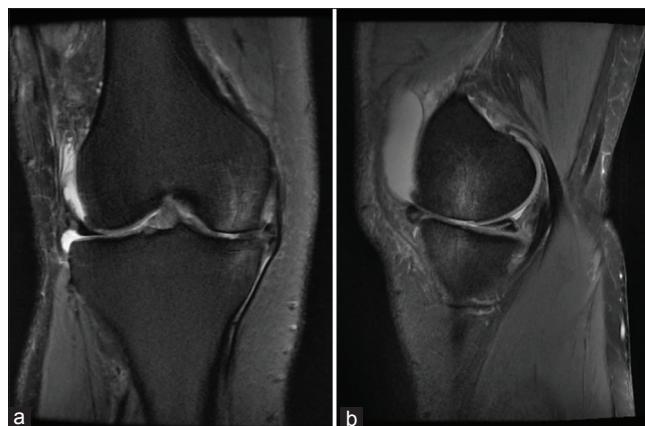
Coronal and sagittal PDFS MRI knee images showing “kissing contusions” on medial femoral condyle and medial tibial plateau in hyperextension injury. Grade II MCL sprain is also seen. (b) Medial meniscus extrusion and Grade II tear of posterior horn of medial meniscus in same patient. Joint effusion is also noted
